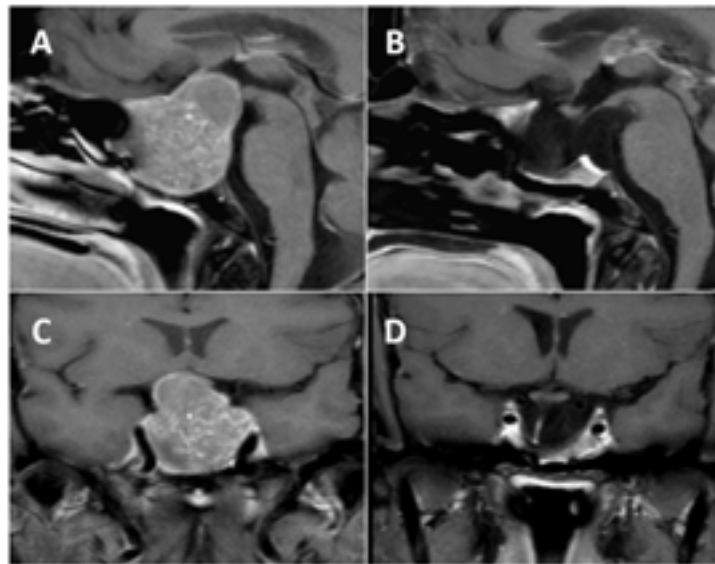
MRI showing complete resection of pituitary tumor.
